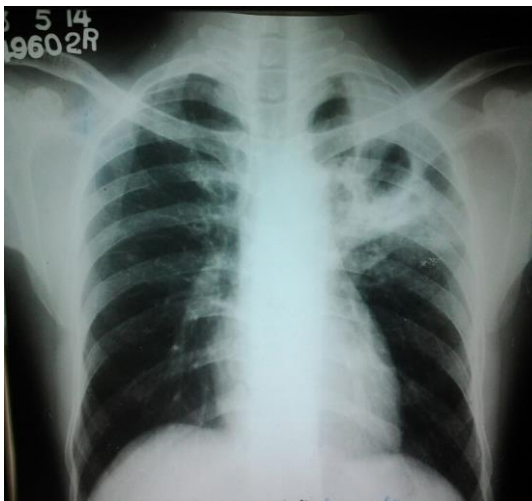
Chest radiograph showing a consolidation with cavity formation in the left upper lobe
